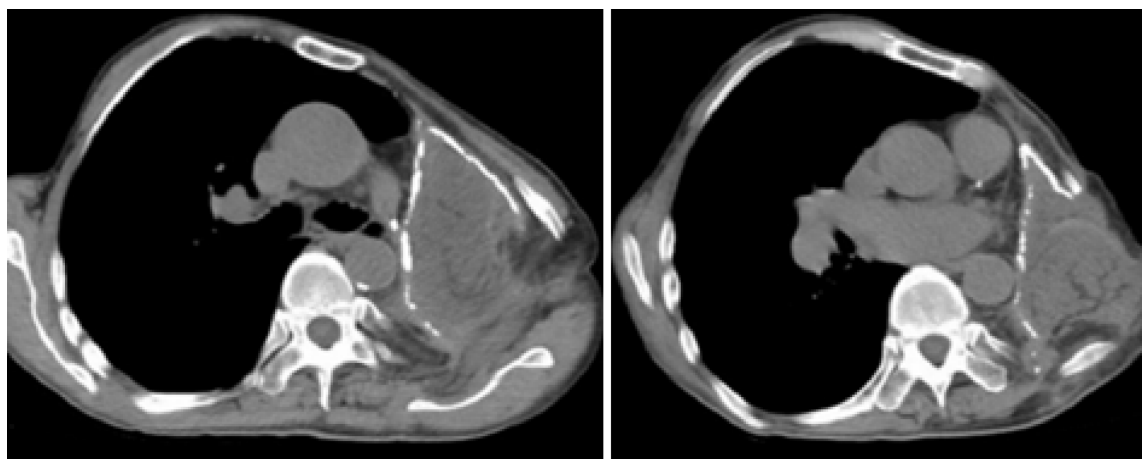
Postoperative chest computed tomography scan (axial view) showing successful obliteration of the empyema cavity by limited thoracoplasty and free vastus lateralis musculocutaneous flap transposition.
